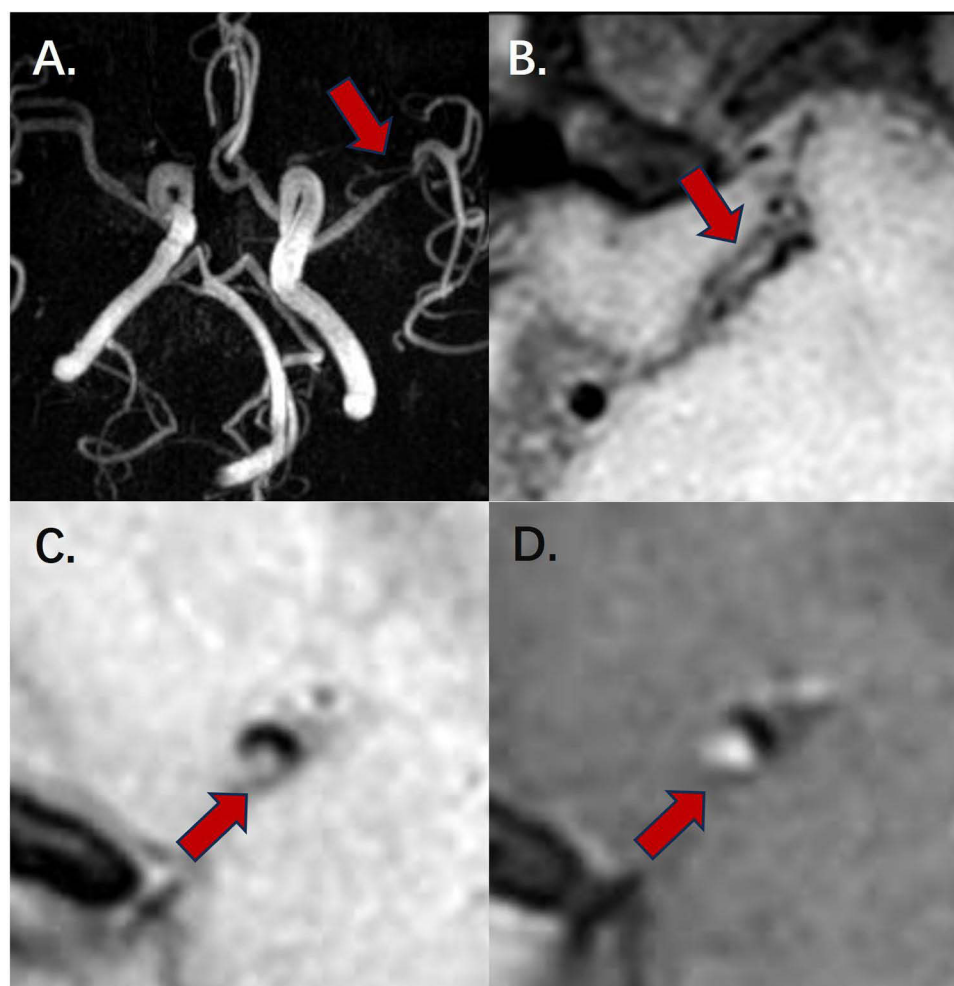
High-resolution magnetic resonance imaging of a plaque in the left middle cerebral artery.
